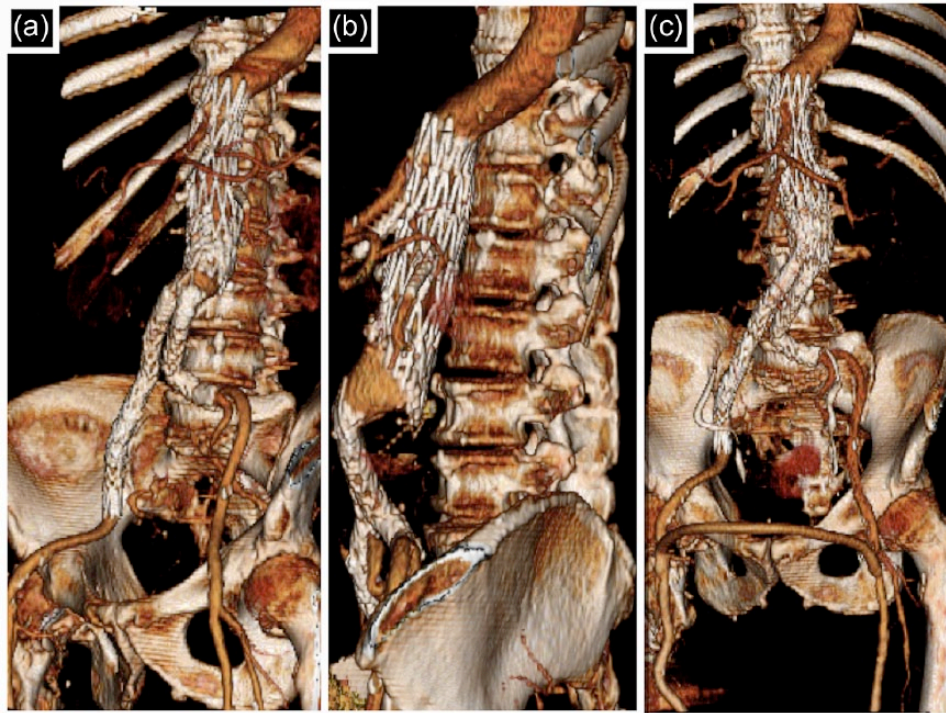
(a) Pre-operative CT 3D reconstructions showing the 18-mm gap between the proximal f-EVAR and bilateral iliac limbs. (b) “Off-ended” orientation of the graft and its limbs can be appreciated in the lateral view. (c) Subsequent conversion to right aorto-uni-iliac stent with femoral–femoral artery bypass.
